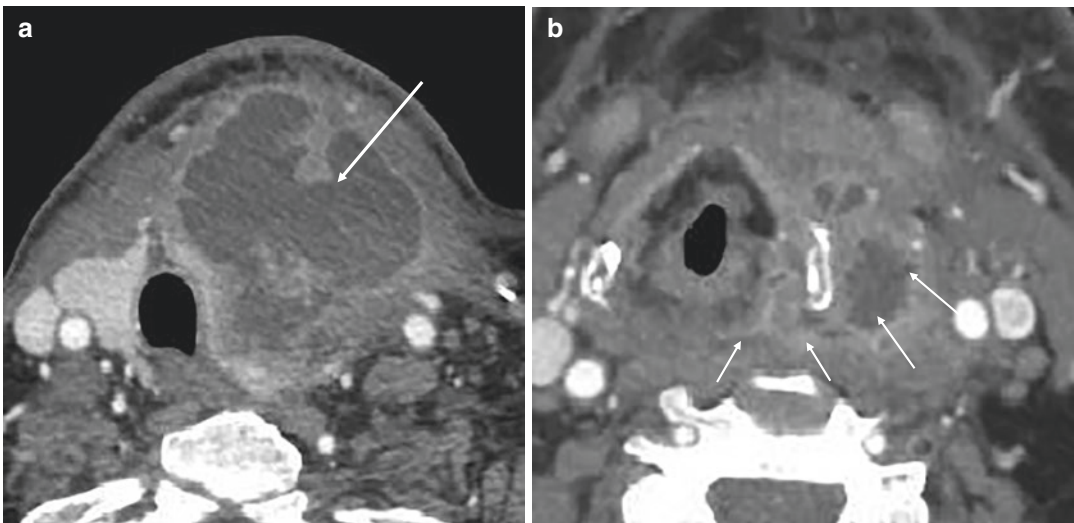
Infection of a left fourth branchial cleft anomaly (sinus) (a) Axial CECT demonstrating a rim enhancing abscess in the visceral space involving the left thyroid gland and tissues beyond (white arrow). (b) Axial CT at
